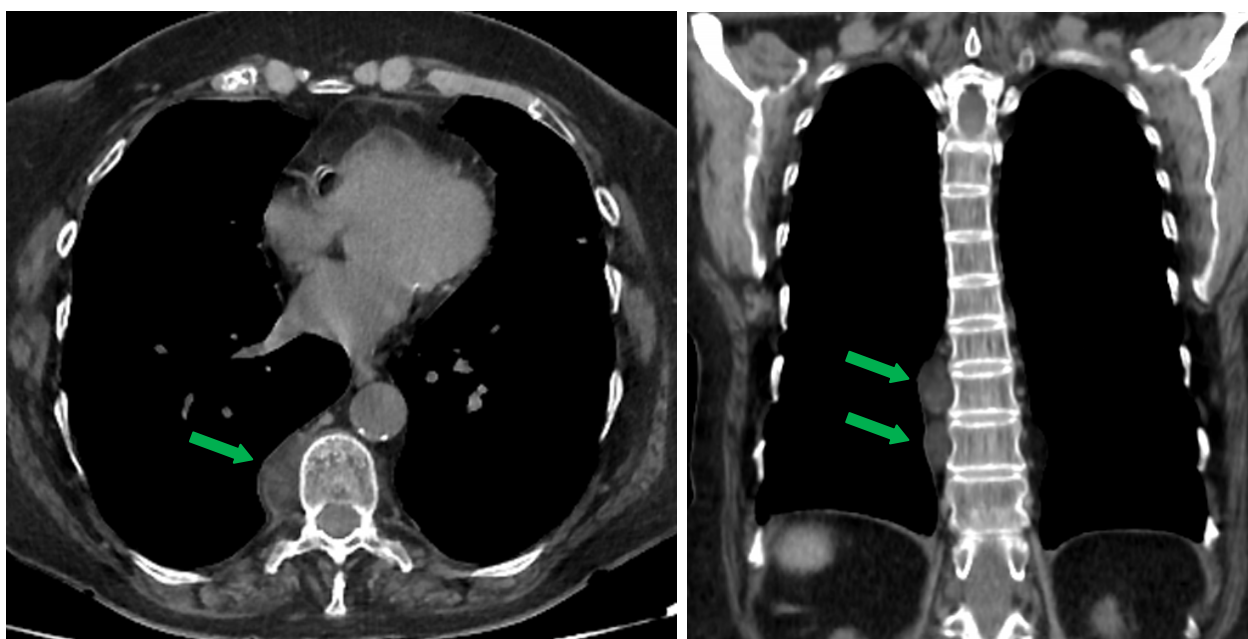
High-resolution CT scan. A. axial. B. coronal. Paravertebral masses, well circumscribed, with fat density, compatible with lymphangioleiomyomas (green arrows).
